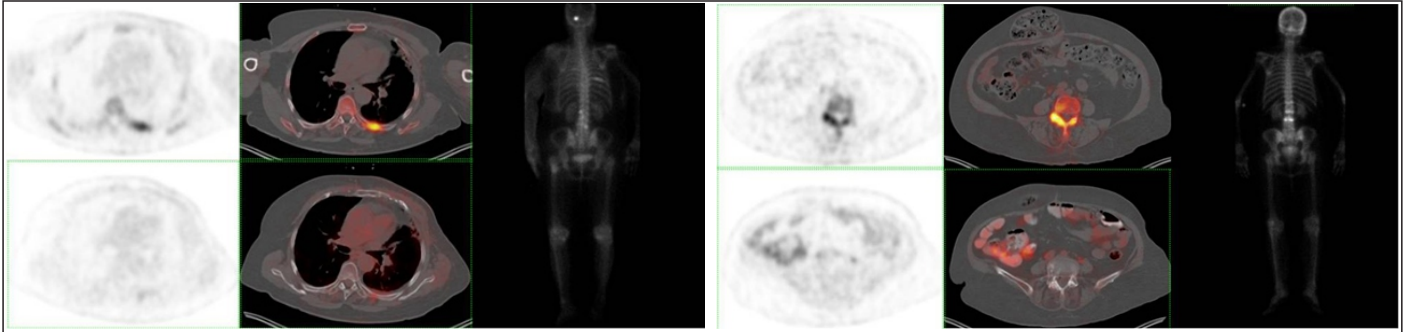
The patient with diagnosis of breast carcinoma, the severity of metastatic involvement is significantly different in the and sodium fluoride (NaF) positron emission tomography/computed tomography (PET/CT) NaF PET/CT compared to bone and fluorodeoxyglucose FDG PET/CT imaging and the follow-up NaF study showed significant progression.
